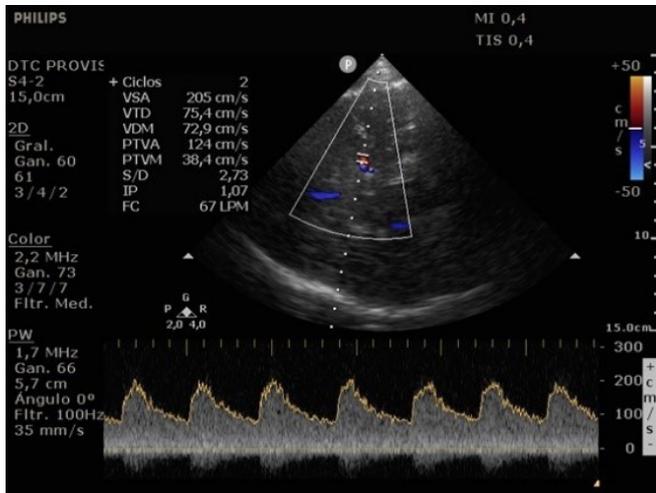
Transcranial ultrasonography of the middle cerebral artery.
